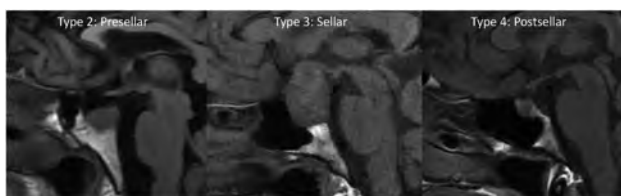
Precontrast T1-weighted sagittal images show the 3 types of sphenoid sinus pneumatization seen in our patients. Type 2 (presellar): the posterior wall of the sphenoid sinus is in front of the anterior wall of the sella turcica; type 3 (sellar): the posterior wall of the sphenoid sinus is between the anterior and posterior wall of the sella turcica; type 4 (postsellar): the posterior wall of the sphenoid sinus is located behind the posterior wall of the sella turcica. An example of type 1 (conchal type, minimal air in the sphenoid sinus) is not shown because this is uncommon and we did not have a patient with this pneumatization pattern.
